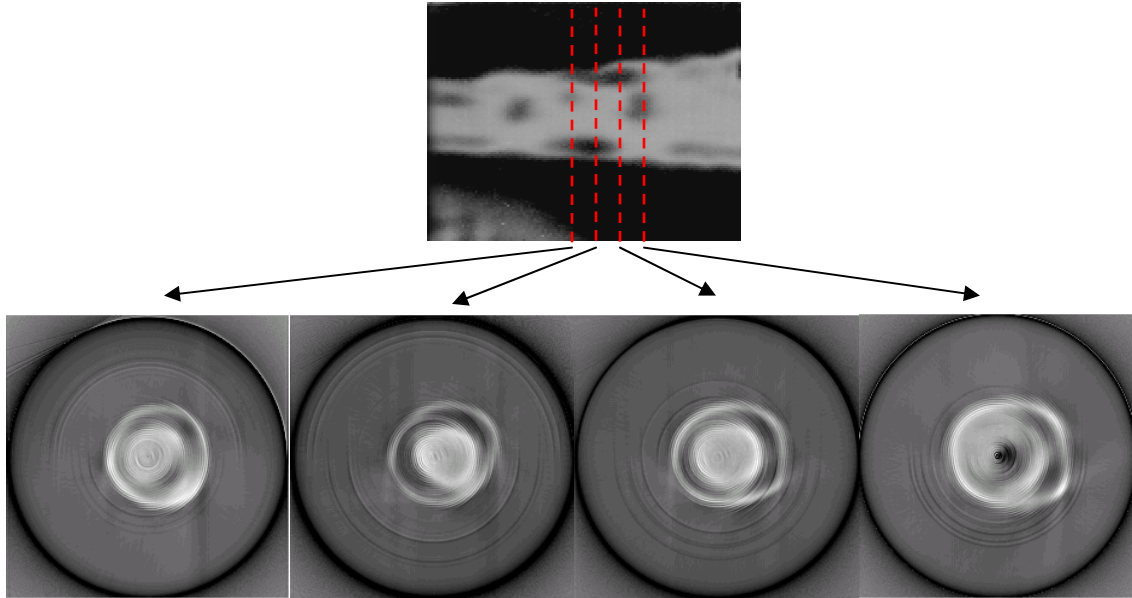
Reconstructed ultrasound CT images. Each ultrasound CT image represents a slice of the target in the position of the dashed line on the C-scan image.
